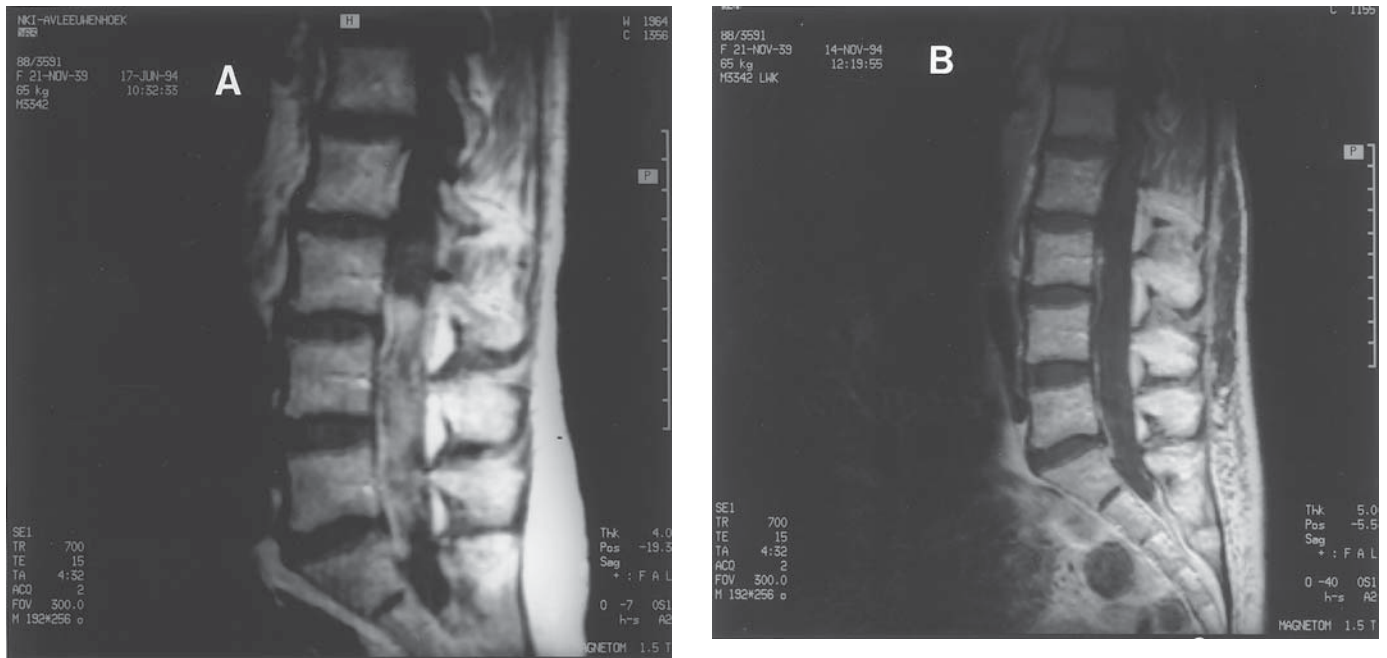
Leptomeningeal metastasis; response to local RT and systemic chemotherapy. The pretreatment postcontrast T1, weighted MRI (A) shows that the lumbar subarachnoid space is filled with tumor with thickening of the nerve roots. After local RT and systemic CMF chemotherapy near-complete disappearance of intradural tumor (B). The patient survived 48 mo with only slight residual neurological impairment without intrathecal treatment.
